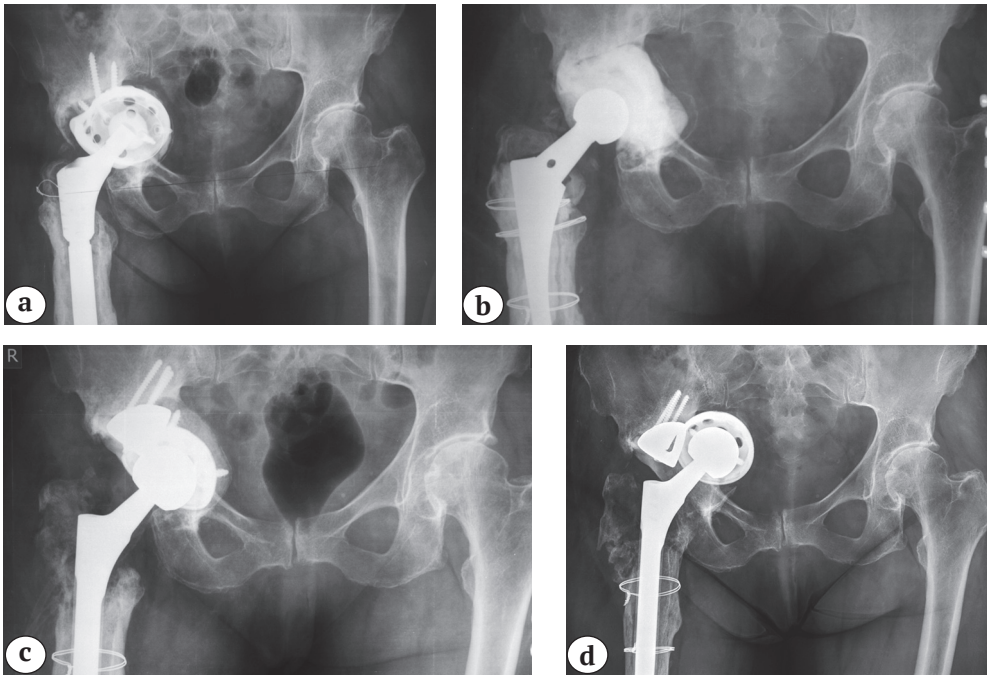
X-rays of female patient 70 y.o.:
